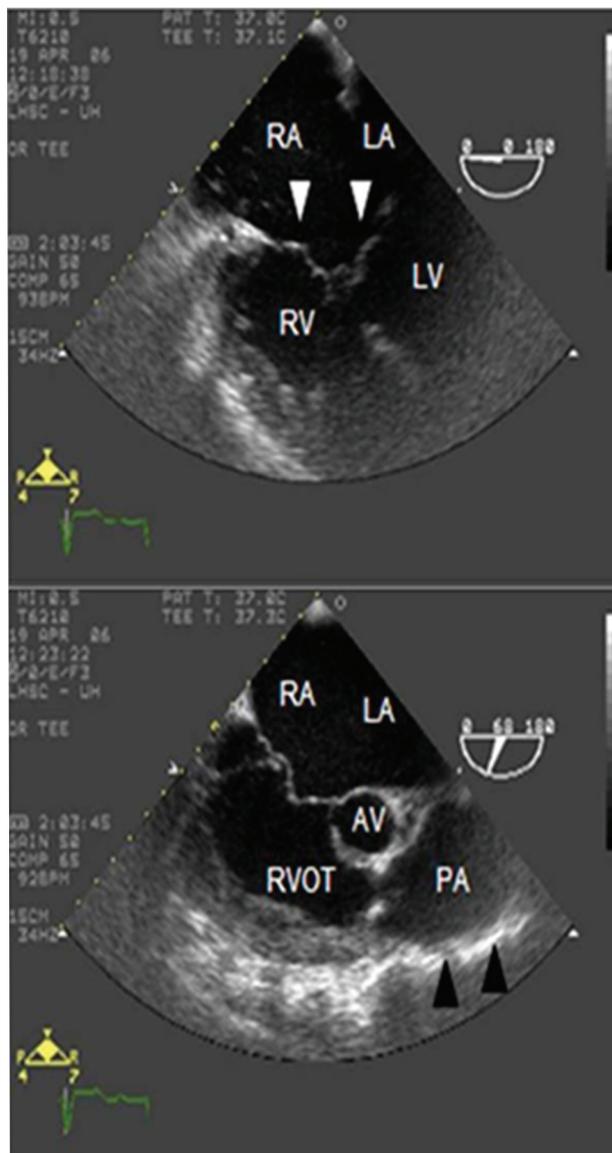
Intraoperative, transesophageal echocardiography: *Upper Panel:* Four- chamber view showing complete AV canal defect and common AV valve (white arrows). RA = right atrium; LA = left atrium; RV = right ventricle; LV = left ventricle. *Lower Panel* RV inflow/outflow view showing post-stenotic aneurysmal dilation of the main pulmonary artery (black arrows) measuring 50 mm in width. AV = aortic valve; RVOT = right ventricular outflow tract; PA = pulmonary artery.
